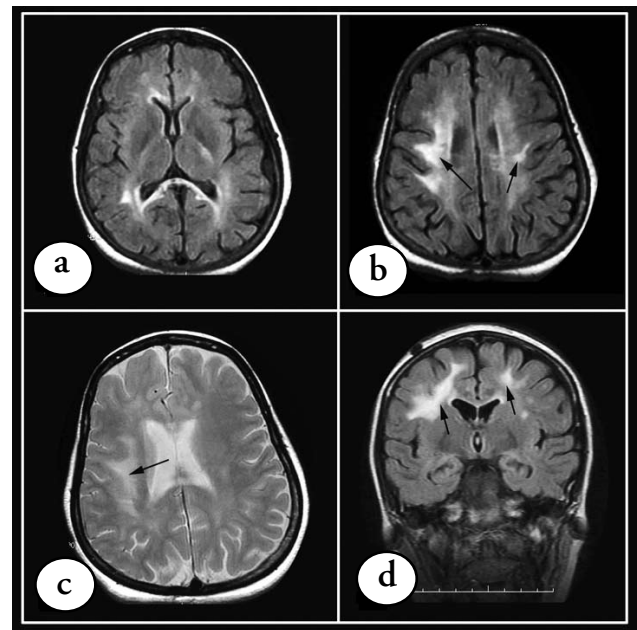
Brain MRI fluid-attenuated inversion recovery (FLAIR) sequence (A, B, D) and proton density (C) showing the confluent periventricular white matter lesion (arrows).
